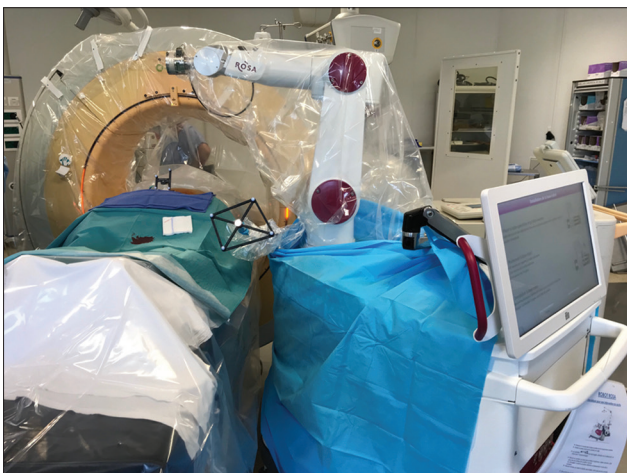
Installation of the patient, the O-arm computed tomography device and the ROSA® robot
